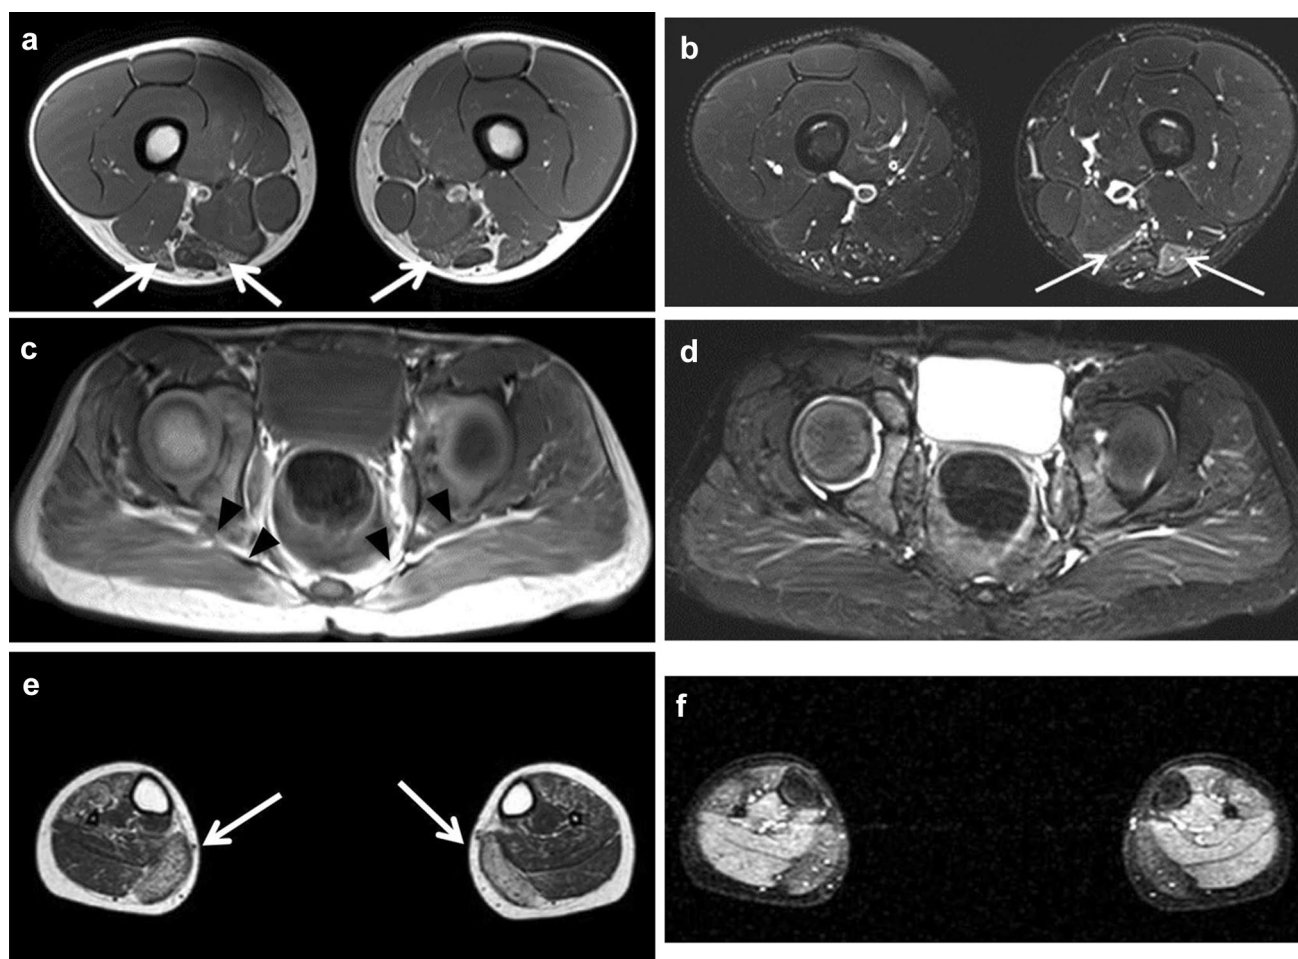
Representative examples of key features evaluated in muscle MRI. Case 1: 16-year-old male patient with suspected facioscapulo-humeral muscular dystrophy (FSHD) presenting with lagophthalmos, horizontal smile, winging scapulae, horizontal clavícula, limited upper limbs abduction and mild steppage gait. a T1-weighted image acquired at the level of the thigh shows mild hyperintensity of the right long head of the biceps femoris muscle (arrows) and of both semimembranosus muscles, consistent with fat infiltration. b T2/STIR image acquired at the same level of the thigh showing hyperintensity of the left long head of the biceps femoris muscle and mildly of the semimembranosus of the same side, as a radiological sign of intramuscular edema (arrows). These findings were mentioned in structured report. Patient also showed fat infiltration of muscles of the upper girdle on MRI (not shown). Based on the presence of specific clinical symptoms and MRI findings, molecular analysis was performed and showed a D4Z4 allele of 17 Kb, as seen in FSHD. Case 2: 5-year-old male child with suspected Duchenne muscular dystrophy presenting with waddling gait, calf pseudohypertrophy, positive Gowers' sign, and elevated serum creatine kinase. c T1-weighted
